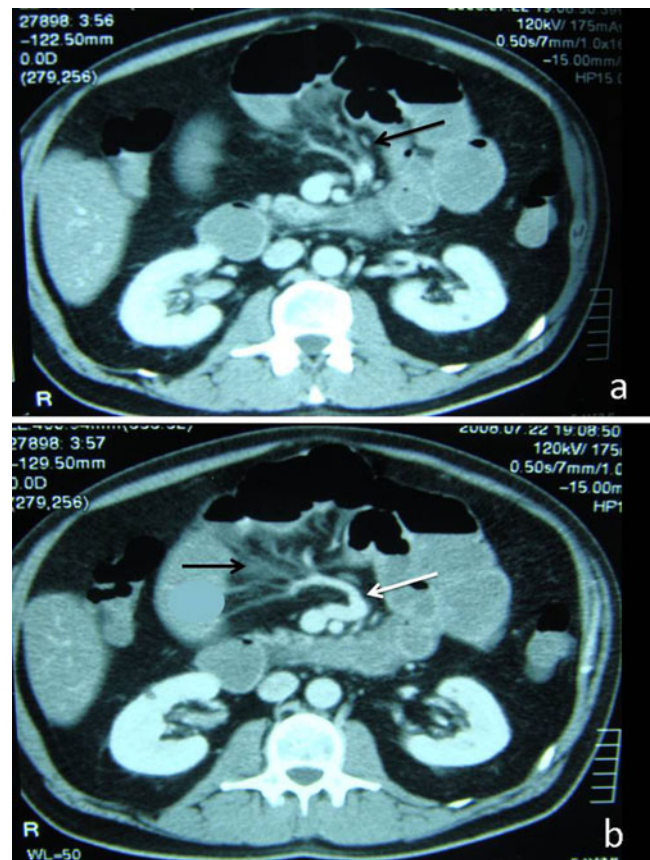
Abdominal computed tomography demonstrating dilated small-bowel loops, with a thickening of the involved mesentery (*black arrow*) and b “clockwise” rotation of branches of the superior mesenteric vein (*white arrow*) around the superior mesenteric artery (“whirl sign”)
